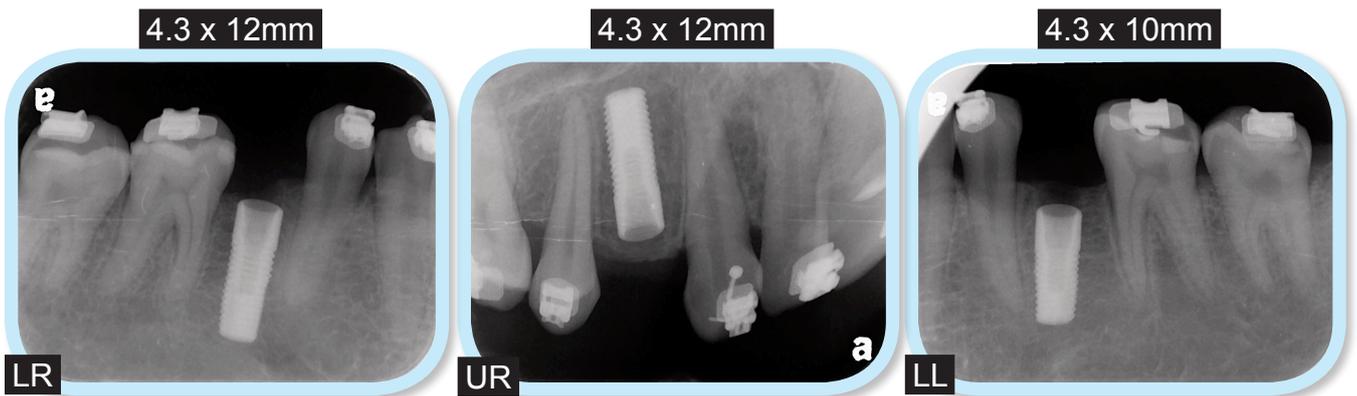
Periapical radiographs confirm adequate implant size and position for all three second premolar areas (LR, UR and LL).
